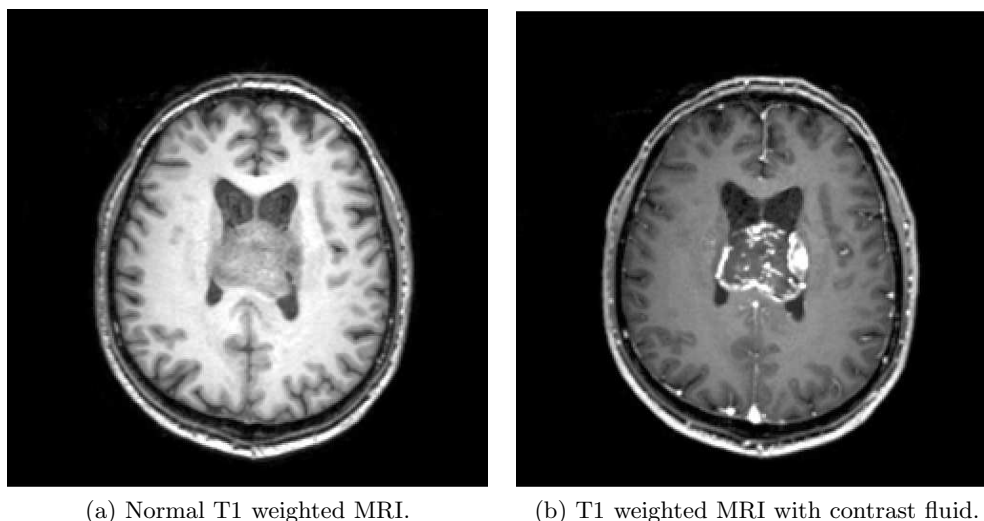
Corresponding slices from two MRI volumes of the same patient. Contrast fluid is used to highlight the tumor in the center of the image (Courtesy of SINTEF MedTech)
